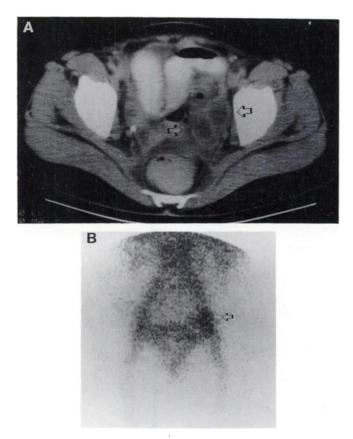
Patient 10, a 32-yr-old female. Recurrent PID. Left lower quadrant pain responded immediately to intravenous antibiotics. Indium-111-IgG revealed residual infection or inflammation. Following continued improvement, patient was discharged. (A) Pelvic CT with complex left adnexal mass (arrows). (B) Indium-111-IgG 6-hr image with left ovarian activity (arrow).
